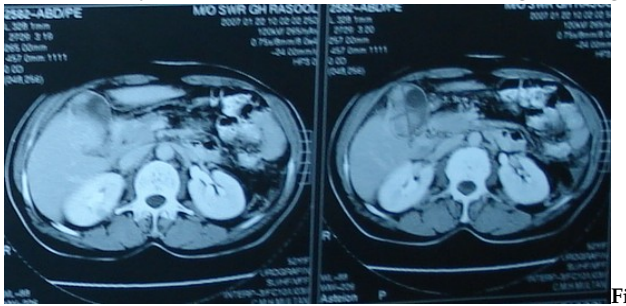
CT Scan showing Carcinoma of Gall Bladder
